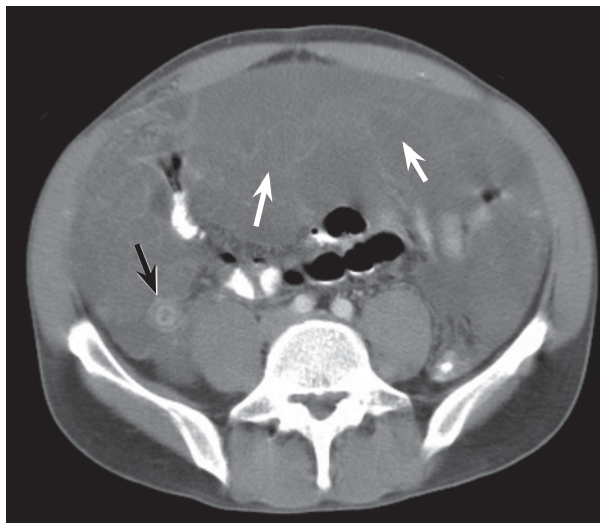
Computed tomography demonstrating massive amounts of septated ascites (white arrows) and a tubular appendiceal structure (black arrow).
